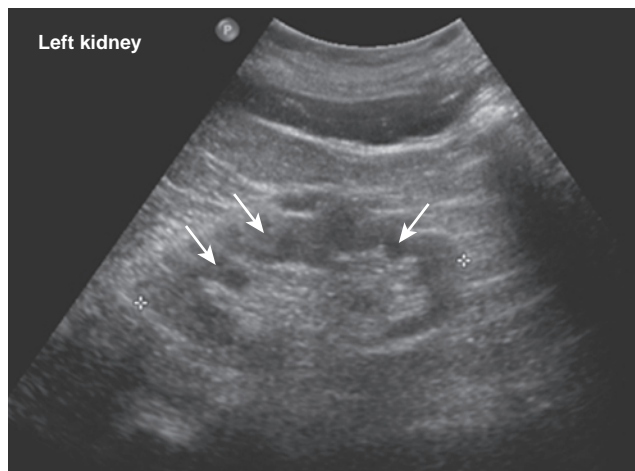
Features of medullary cystic kidney disease. Ultrasonogram demonstrating corticomedullary cysts, some of which are indicated by arrows. The hyperechogenicity is secondary to the tubulointerstitial fibrosis. (From Simms RJ, Eley L, Sayer JA. Nephropthisis. *Eur J Hum Gen* 2009;17:406-16.)
